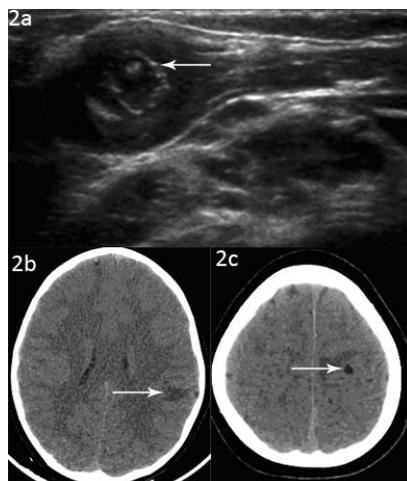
A) USG of Right SCM showing hypoechoic cyst with hyperechoic scolex within the Muscle; B & C) CT Axial plain Brain showing granulomas in the right frontal with scolex (Vesicular) and left parietal region with perilesional oedema
